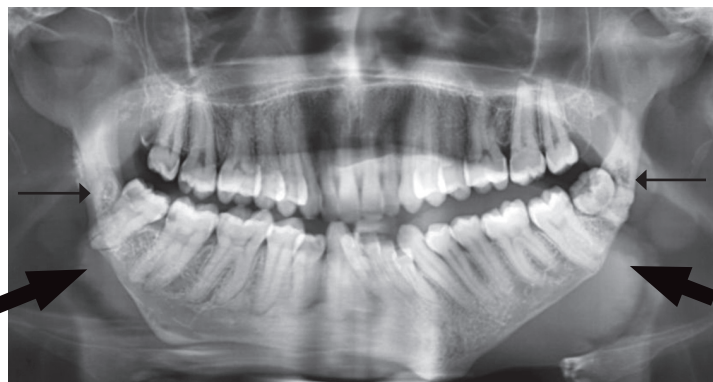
Panoramic radiograph showing resorption of the roots of posterior teeth, ramus, body and angle of the mandible. Thick and thin arrow indicating calcifications of the sub-mandibular glands and bilateral pathological fractures respectively.
